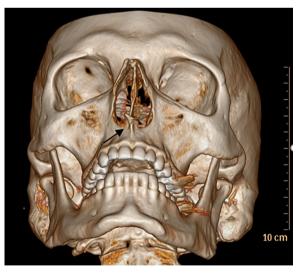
CT scan of the face with 3-dimensional reconstruction depicts an anterior nasal spine fracture with mild displacement to the right (arrow).
